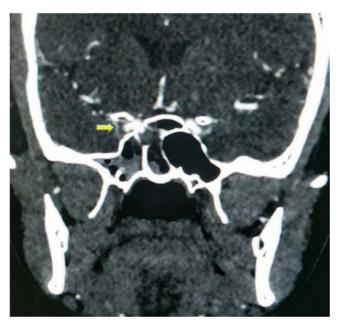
CT angiogram shows a right carotid siphon pseudoaneurysm protruding into the sphenoid sinus through the traumatic bony defect (arrow).
